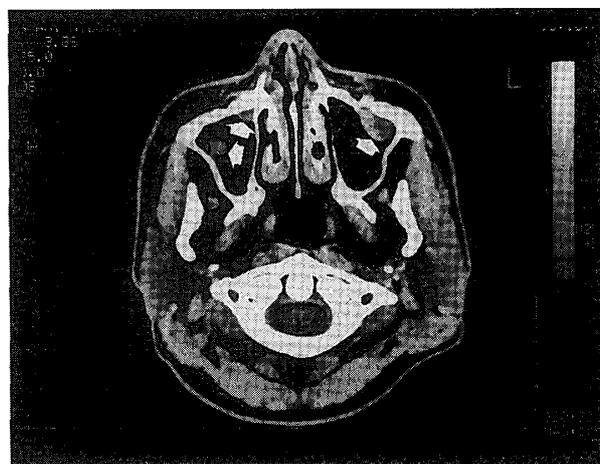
Computed tomograph at the initial visit to the clinic (1992) showing masses projecting into both maxillary antrum (arrows).
